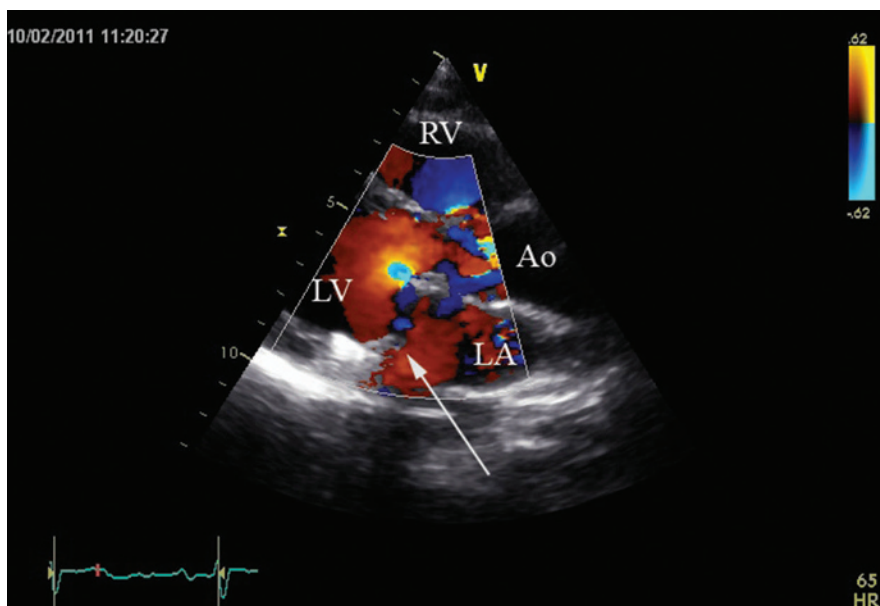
Sample transthoracic echocardiogram with color Doppler imaging, parasternal long axis view. The Amplatzer™ Vascular Plug III (St. Jude Medical, St. Paul, MN) positioned in dehiscence (arrow). No paravalvular leak shown in color Doppler imaging. Ao, aorta; LA, left atrium; LV, left ventricle; RV, right ventricle.
